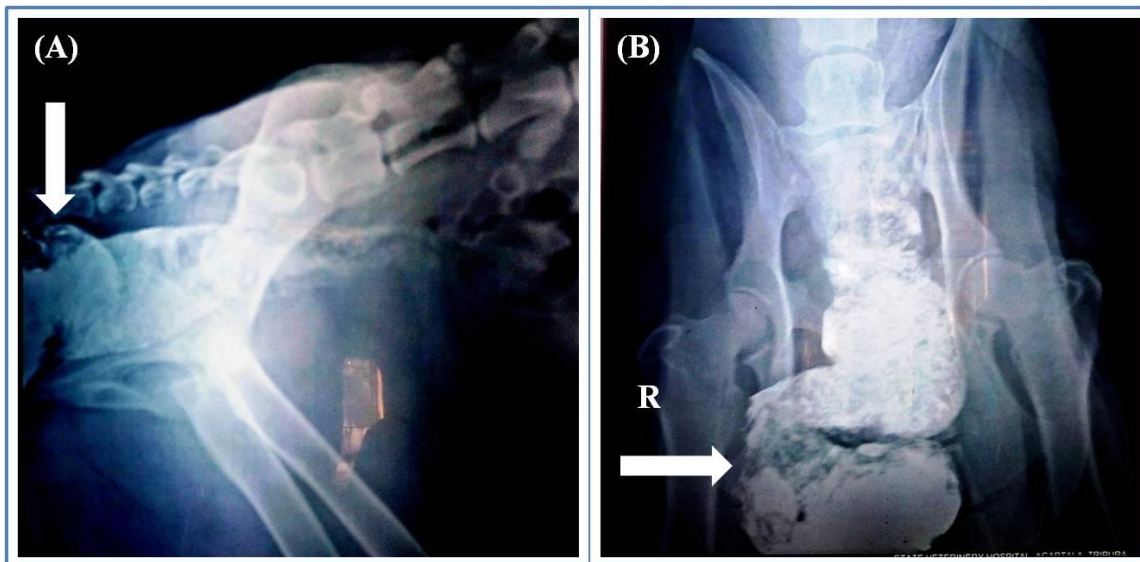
(A) Contrast radiography in right lateral projection and (B) Contrast radiography in ventro-dorsal projection of marked solitary diverticulum (white arrows indicate rectal diverticulum).
